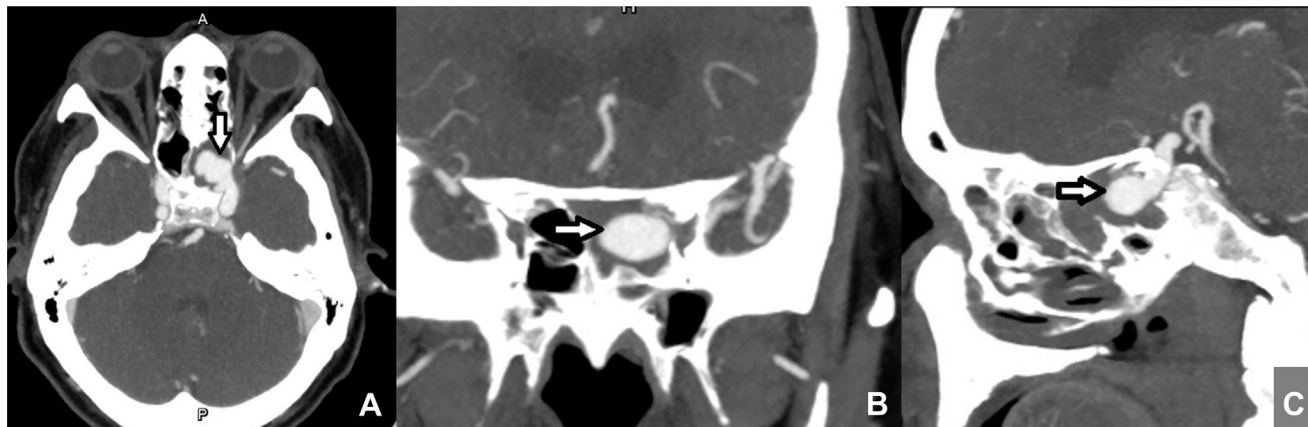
Preoperative images. (A) Axial, (B) coronal, and (C) sagittal view computed tomography angiography shows a saccular aneurysm of the cavernous segment of the left internal carotid artery (arrow) protruding into the sphenoid sinus.
